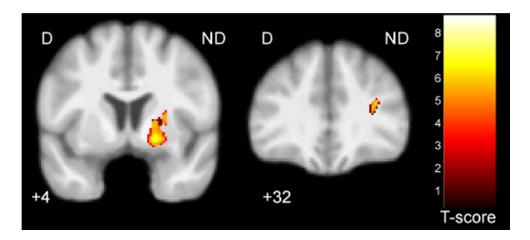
Coronal MRI slices demonstrating the extent of significantly differing gray matter volumes in the striatum in the non-dominant hemisphere (+4) and in the sub-gyral, prefrontal region in the non-dominant hemisphere (+32). The same regions are shown in axial slices in Figure 2. D = dominant hemisphere; ND = non-dominant hemisphere.
